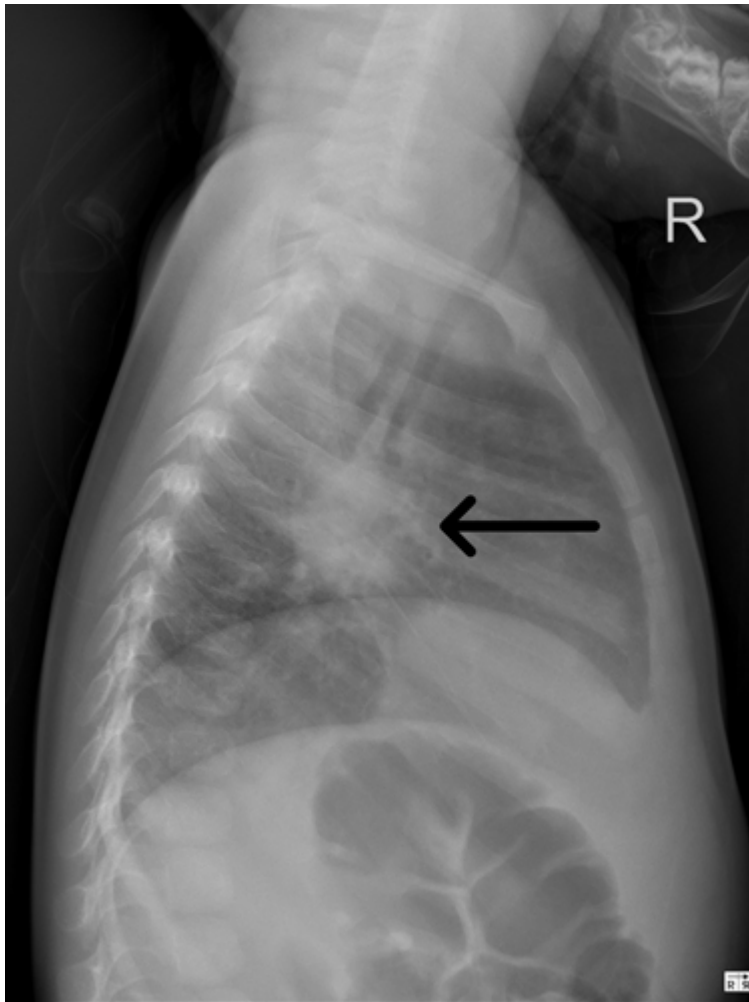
Lateral chest X-ray. LNs confirmed with the doughnut or hamburger sign present (arrow). ↩
